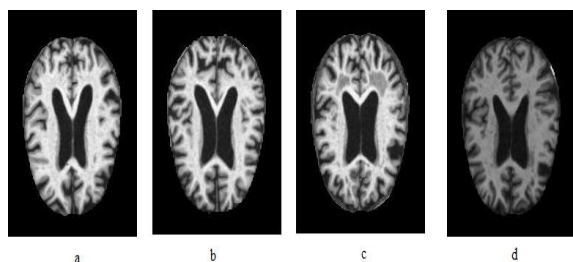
AD presented by MRI images (a) mild dementia; (b) moderate demented; (c) nondemented; and (d) very mild demented.
